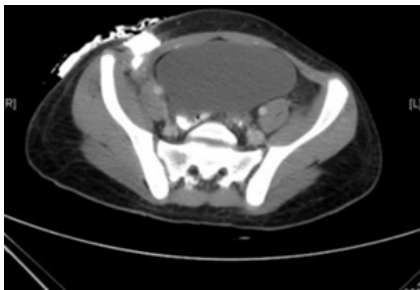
Oral contrast CT scan showing extravasations of contrast dye at the level of the caecum.
